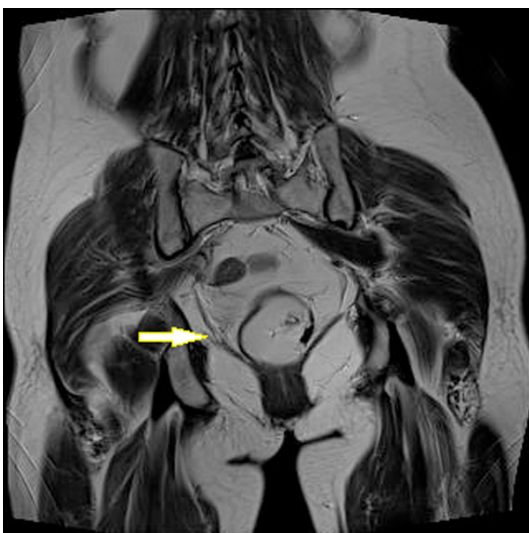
A patient with MRI showing a discontinuity (arrow) between the inferior pubic rami and the puborectalis muscle. The patient with levator ani defect was excluded.
